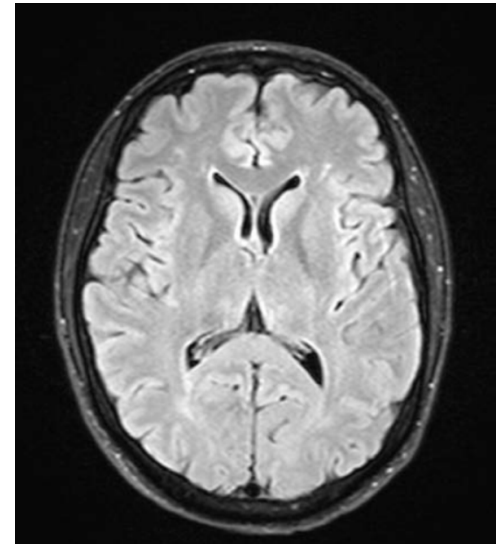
Axial brain image using FLAIR. Courtesy of University of Iowa Carver College of Medicine.
